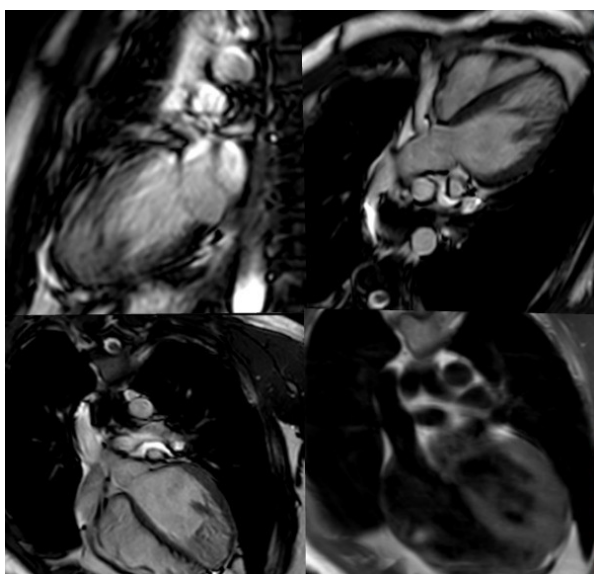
Cardiac MR images of the patient, increased trabeculation structure in the LV apical
